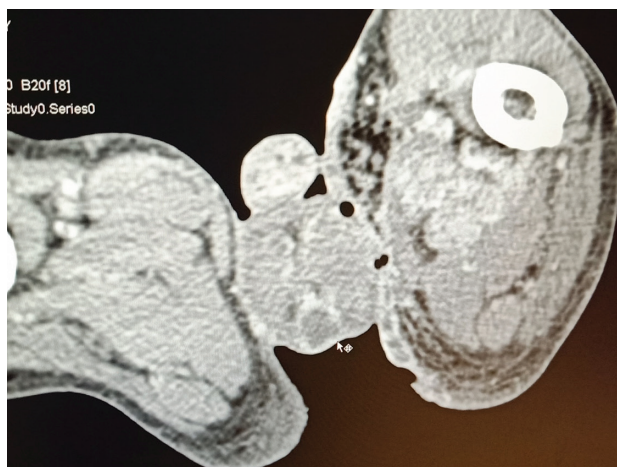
Contrast-enhanced computed tomography scan image of the pelvis showing multiple heterogenous necrotic hypodense foci in the scrotum (white cursor arrow) and soft tissues.
